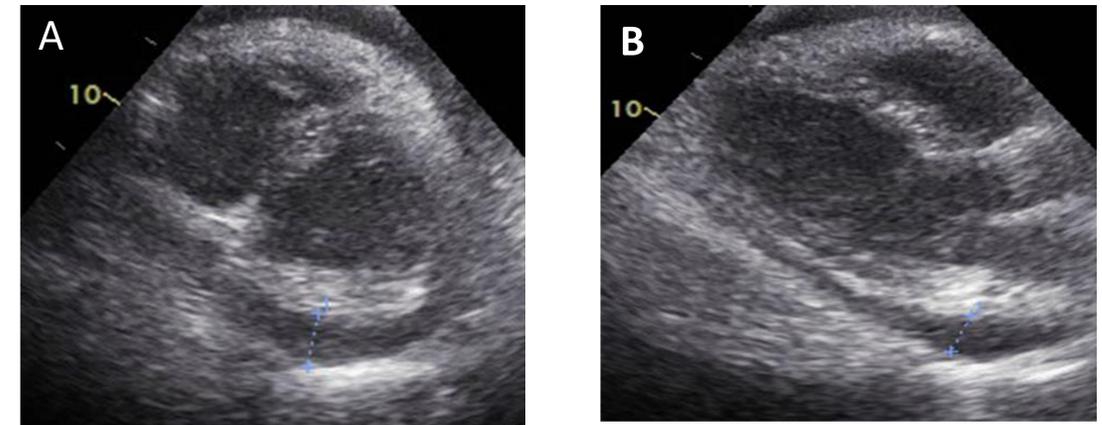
Echocardiogram of the heart (a) parasternal short axis view showing moderate pericardial effusion and (b) left parasternal long-axis view showing pericardial effusion, mild right and left atrial chamber collapse consistent with tamponade.
